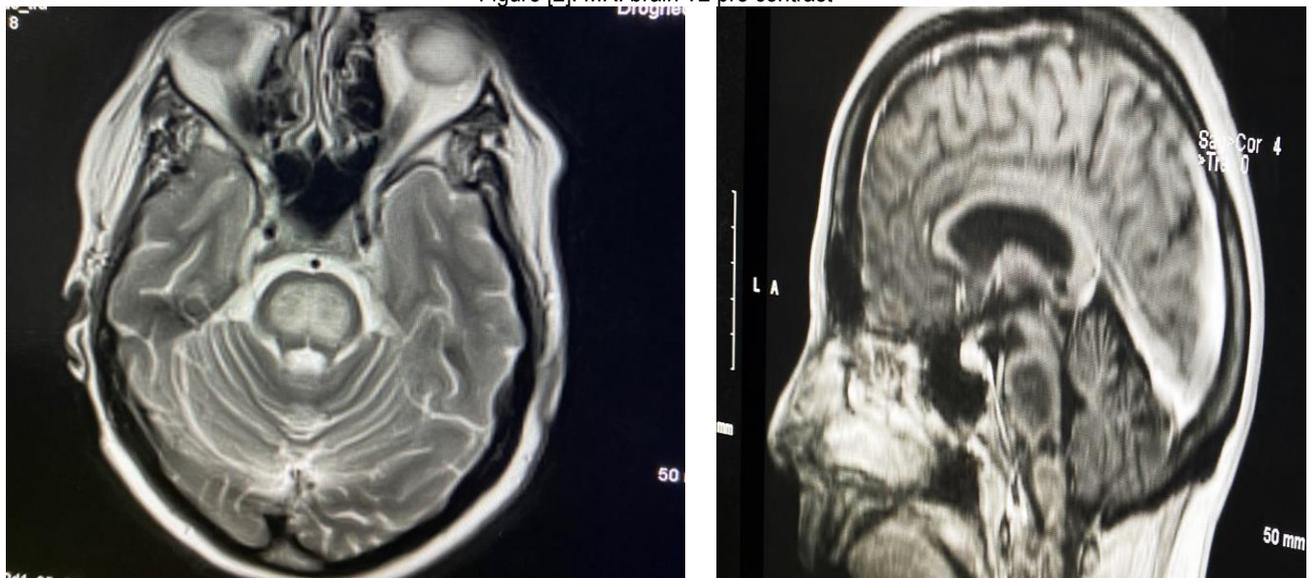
MRI brain T2 post contrast
